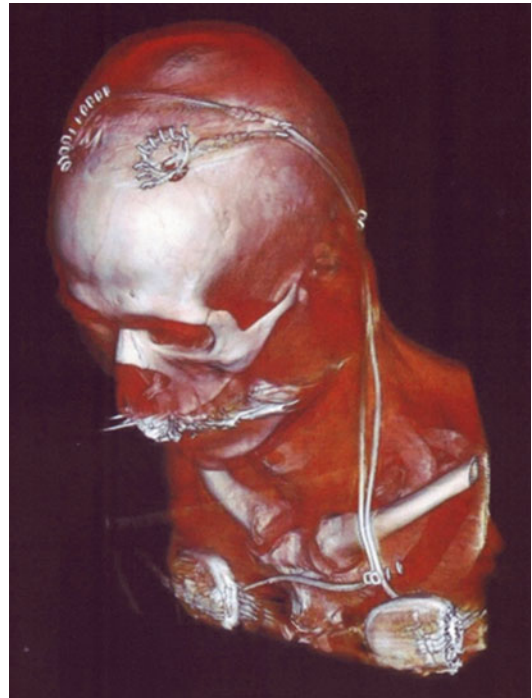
Postoperative 3D-computed tomography (CT) image showing the subcutaneous course of the extension wires and infraclavicular placement of the implantable pulse generators (IPGs)
